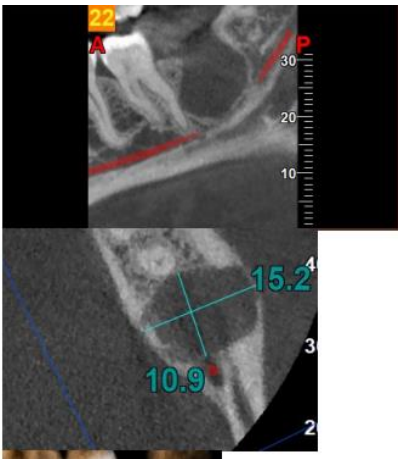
(Showing chronic periapical abscess)
